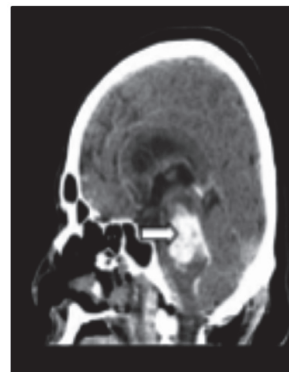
(C): Sagittal Plain CT Brain Image Showing the Pons
